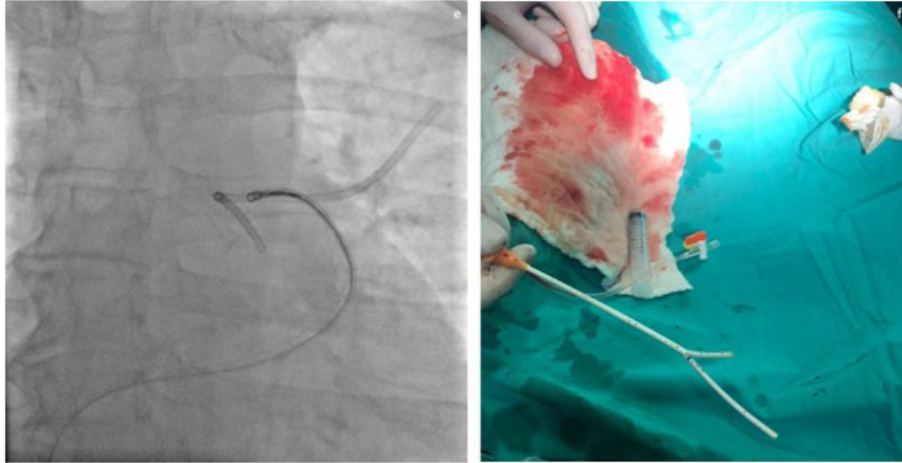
(a) Chest x-ray after TIVAP implantation shows the correct position of it. (b) Approximately 3 years after implantation, a twisting of catheter between the first rib and clavicle, compatible with pinch-off syndrome (arrow) was seen. (c) About 9 month later after (b) image, broken of the catheter from former twisted area and migration of distal part into the left pulmonary artery was detected (arrow). Note the remnant catheter and port reservoir (arrowhead). (d) With right femoral vein approach, the snare kit was moved to the dislodged catheter. (e) The migrated part was captured with snare system. (f) The broken distal part of catheter removed successfully with venous sheath.
